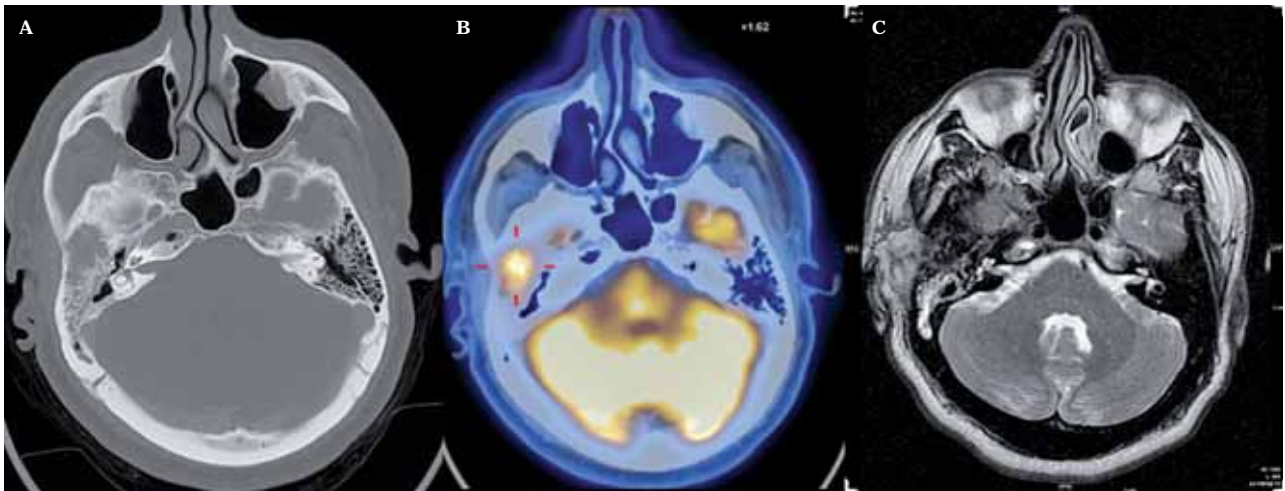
A) Preoperative axial CT scan in bone algorithm shows an ill-defined lytic mass within the right temporal bone. B) Preoperative PET-CT with corresponding area of increased avidity for F18-FDG. C) Preoperative axial T2-weighted imaging reveals predominantly hypointense right temporal mass.
